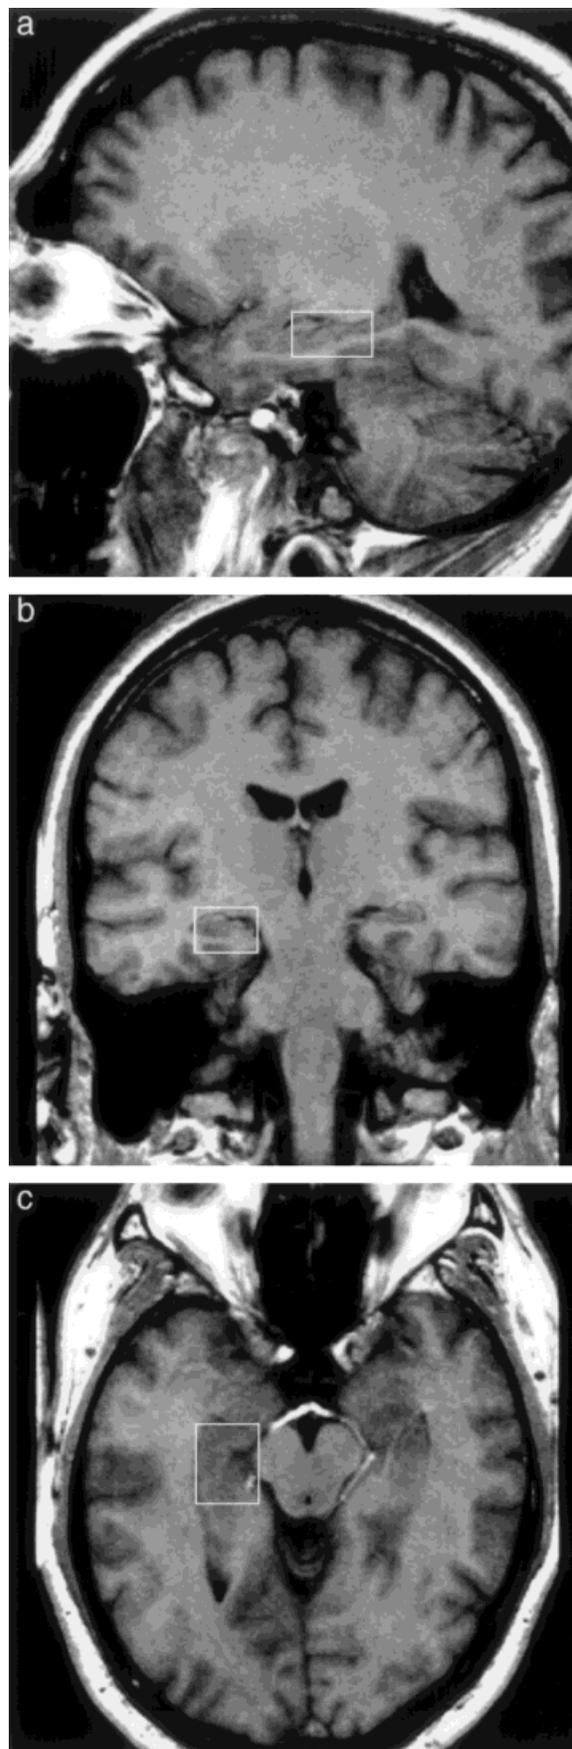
a–c: T1-weighted MR images showing a typical VOI ($13 \times 18 \times 23 \text{ mm}^3 = 5.4 \text{ mL}$) selected for proton MRS of the human hippocampus (RF spoiled 3D FLASH, TR/TE 15/6 msec, flip angle 20°).
